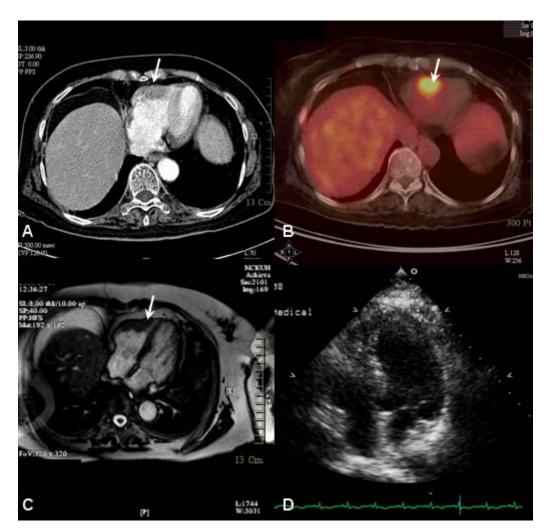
A: A soft tissue nodular lesion in RV free wall by chest CT (arrow) but ignored initially, B: A hypermetabolic lesion in RV by PET/CT (arrow), C: A nodule with isointensity to myocardium of the RV wall (arrow), D: TTE failed to exhibit obvious lesion in the heart chamber
